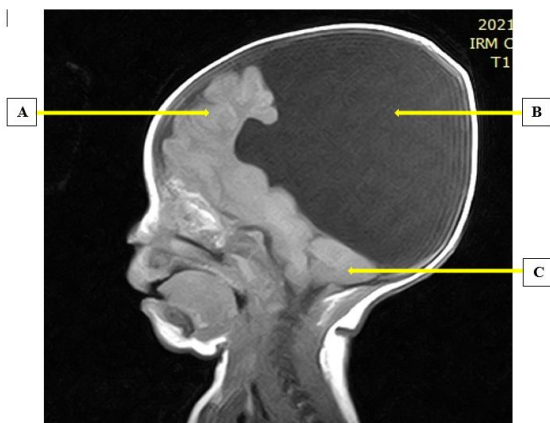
MRI scan of the encephalon in sagittal section displaying a single dilated supratentorial cavity pushing forward the remaining cerebral parenchyma: A= Remaining cerebral parenchyma, B= Single dilated cavity, C= Cerebellum (little brain)
